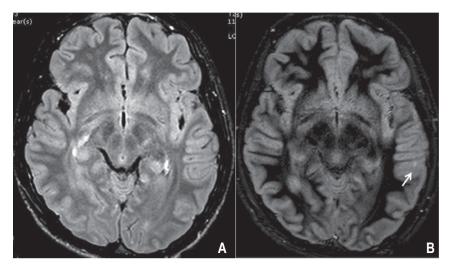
Double inversion recovery (DIR) in multiple sclerosis: (A) FLAIR, (B) DIR show lesion in the gray matter of cerebral cortex on DIR (arrow in B) which is not seen on FLAIR.
